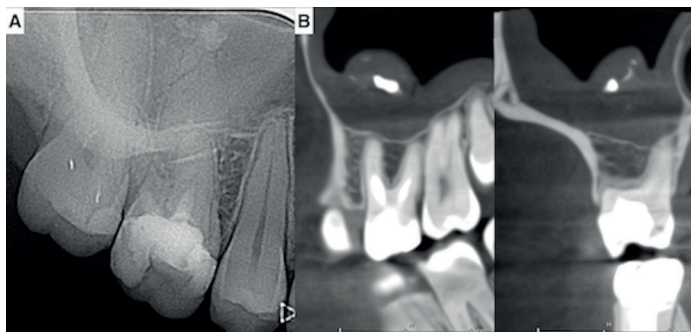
Aspergillus sinusitis. A, Preoperative radiograph showing a lesion associated with the palatal root, from which the extrusion of the root filling materials occurred in the maxillary sinus.
